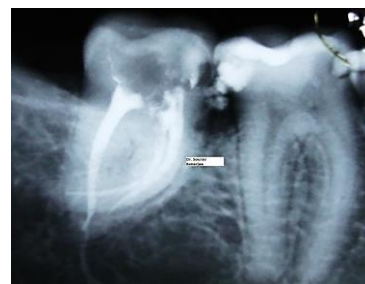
Preoperative radiograph showing the separated fragments(a) & dilacerated canal(b) in relation to #37
